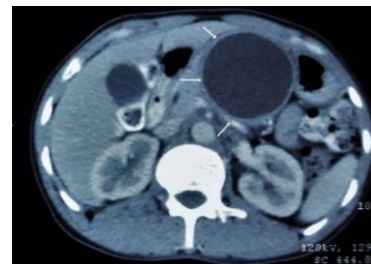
(case 5): Contrast enhanced CT abdomen (axial section) showing well defined round cystic lesion of size approximately 5.5 × 5.7 cm (thick white arrow), near pancreatic body causing compression to the stomach and pancreatic parenchyma (thin white arrow showing enhancing margin of cyst).
